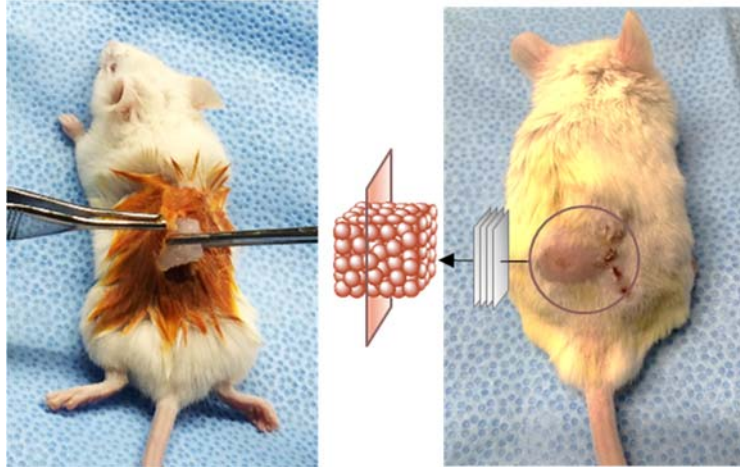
MRI scan. Stacked sagittal scans of the implanted constructs.
